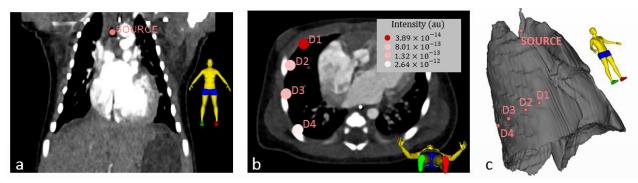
Coronal and sagittal slices (a, b) and 3D lung model (c) from a CT scan of a 3.7 kg infant with light source placed inside the trachea and detectors (D2, D2, D3 and D4) over the external surface of the lung in the same sagittal plane.
